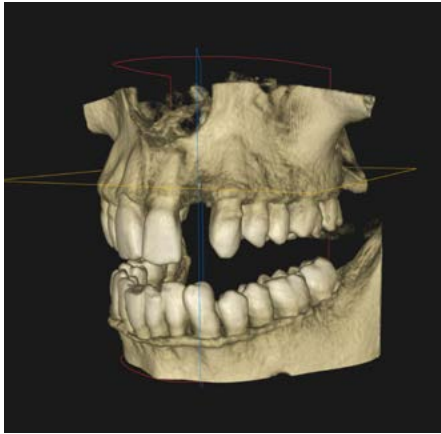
3D Render showing UL2 region from CBCT scan
